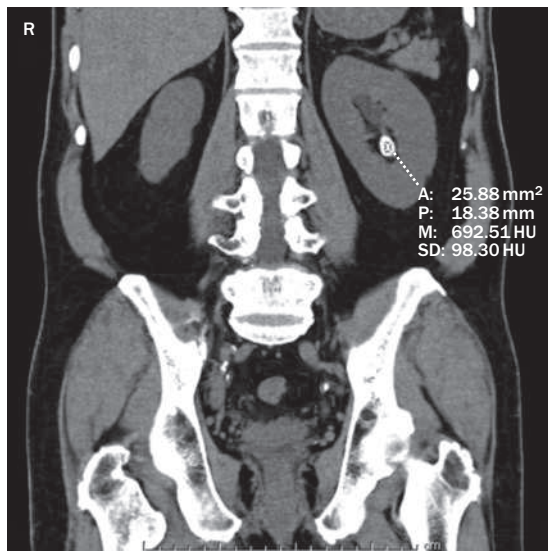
CT scan from a patient with a 1.5 cm stone in the lower pole of the left kidney. The stone had a low attenuation value of 692 HU, suggesting that it would fragment easily. However, the stone could not be fragmented after two sessions of extracorporeal shockwave lithotripsy (ESWL). After endoscopic treatment, chemical analysis of the stone revealed that it was composed of calcium oxalate monohydrate, suggesting that the susceptibility of urinary stones to fragmentation by ESWL cannot be accurately determined by CT attenuation values alone.
